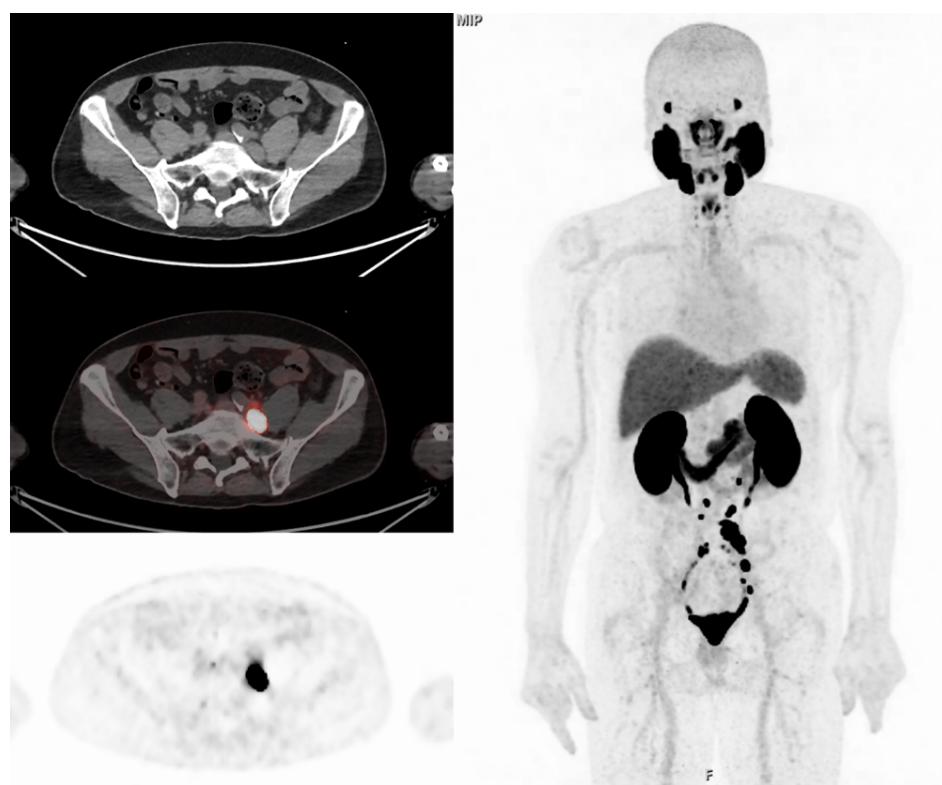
PSMA PET/CT (using ^{18}F -DCFPyl) in a patient with biochemically recurrent prostate cancer. Axial CT, fused, and PET images show an enlarged left iliac lymph node with intense uptake. MIP image (right) shows bilateral retroperitoneal lymph node metastases. Normal intense uptake is seen in salivary and lacrimal glands, kidneys, and along the ureters and bladder.
